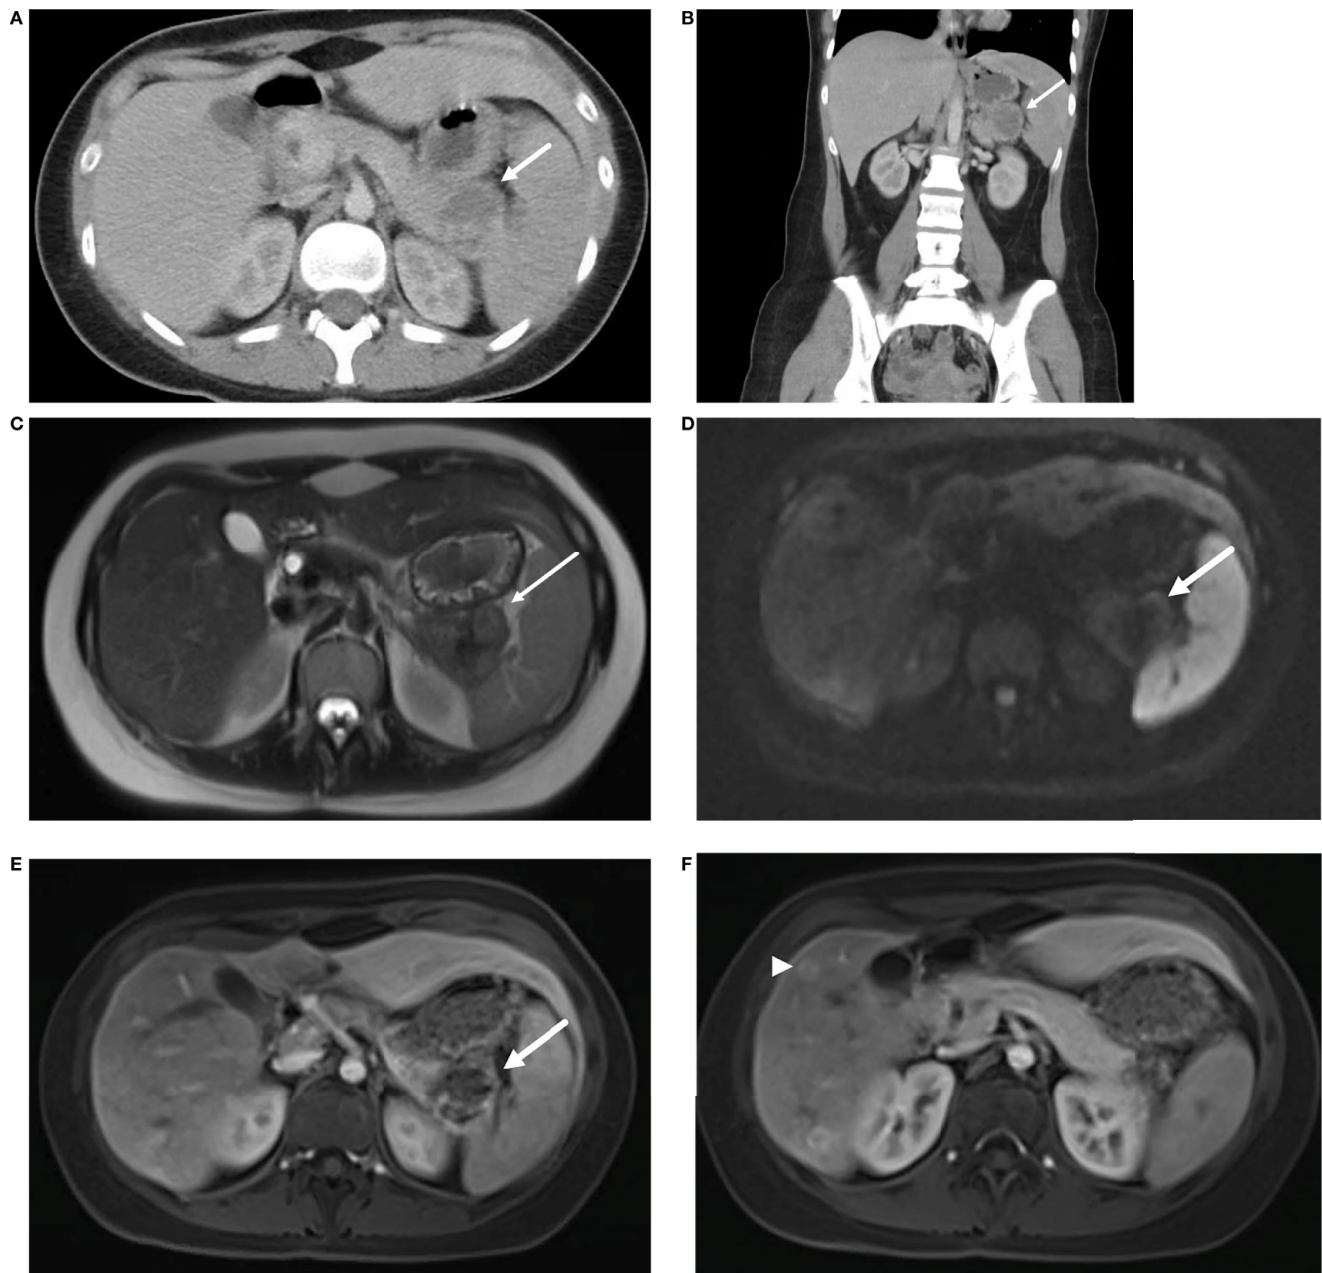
Axial (A) and coronal (B) contrast enhanced CT demonstrate a pancreatic tail mass with central necrosis (→) positioned between the stomach, spleen, and kidney. MRI of the abdomen reveals a mass in the tail of the pancreas (→) with intermediate T2 signal (C), diffusion restriction (D) and peripheral contrast enhancement (E). Additional enhancing lesions (▶) were seen in the liver consistent with metastatic disease (F).
